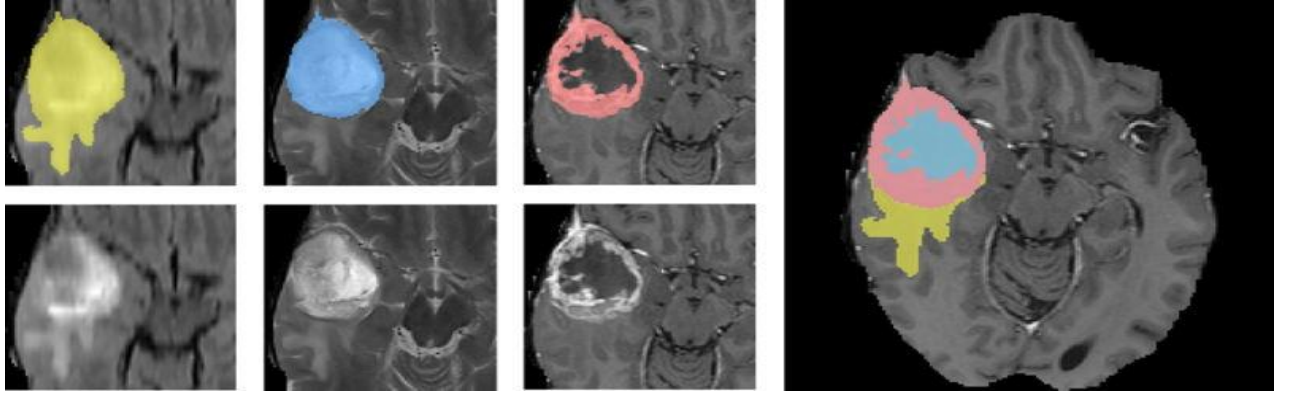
The simple example of a manually marked MRI image on computers with the color marker mark the human brain tumor volume. Left hand side shows the digital images demonstration of human brain tumor image a cut-out with human brain tumor in the cancers patient of the same part in the human brain in three dissimilar MRI 2D digital image orders with three dissimilar interpreted human brain structures which is starts from the left to right hand side the entire tumor, tumor central, and lively tumor is exist in the given image.
